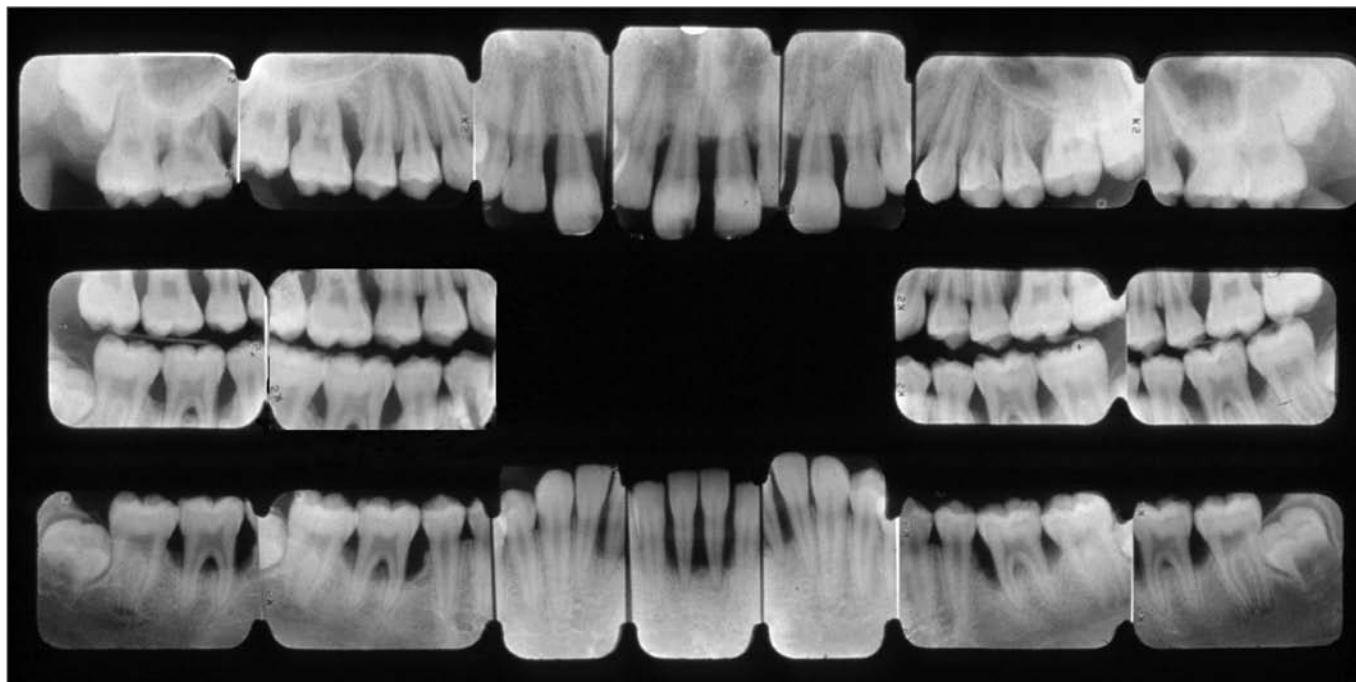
Intraoral radiographs of an adolescent patient with aggressive periodontitis showing vertical bone loss in the molar and incisor regions. (Courtesy Dr. John Moriarty, Cary, N.C.)
